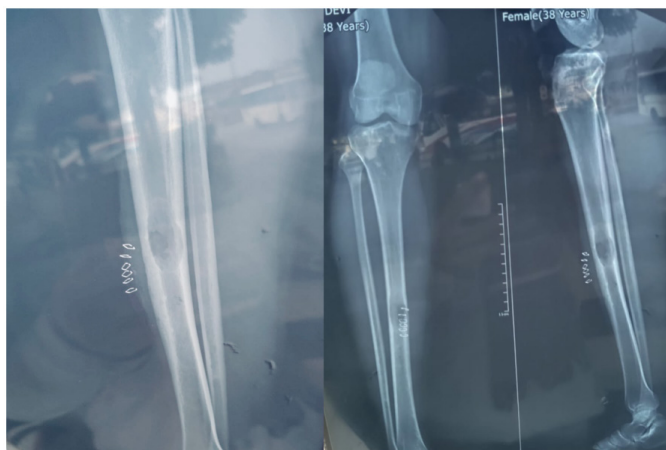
X-ray View of Tibia showing lytic lesion in tibial diaphysis
